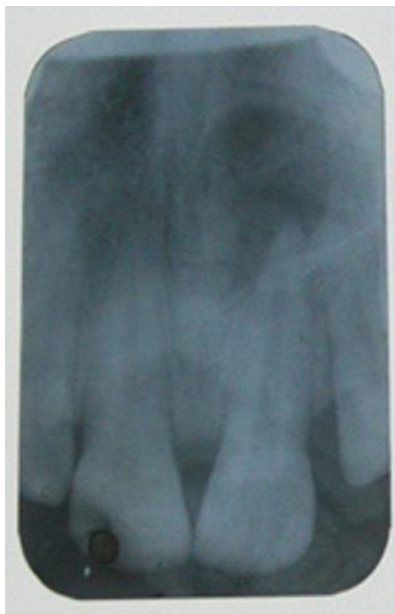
Pre-op periapical X-ray view
